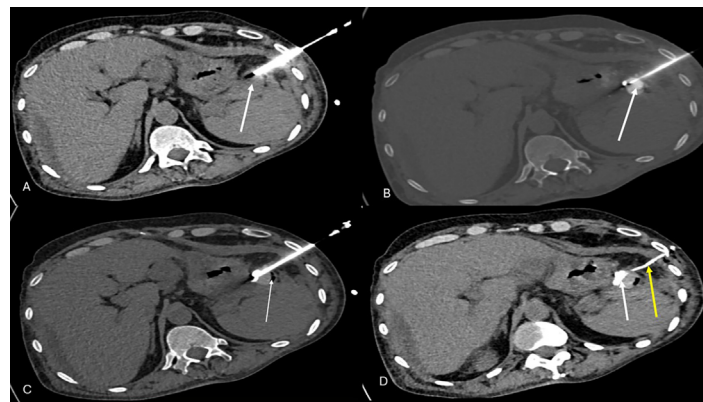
Case 2. Percutaneous CT guided embolization of the pseudoaneurysm with SAMEER technique (A) The pseudoaneurysm sac (white arrow) is punctured with an 18G puncture needle with CT guidance. (B) Axial CT image at the level of the pseudoaneurysm obtained after injection of the mixture of gelatin-based hemostatic foam slurry and autologous blood clot. Note that the sac of the pseudoaneurysm is filled by the embolysate (white arrow). (C) Axial CT image at the level of the pseudoaneurysm after deployment of 2-0 nylon suture “coil”. Note is made of some air trapped within the pseudoaneurysm sac (white arrow) during embolization. (D) Check CT scan obtained after embolization shows stasis of the embolysate within the aneurysm sac (white arrow). Also noted is the embolysate deposited along the tract of percutaneous needle insertion (yellow arrow).
